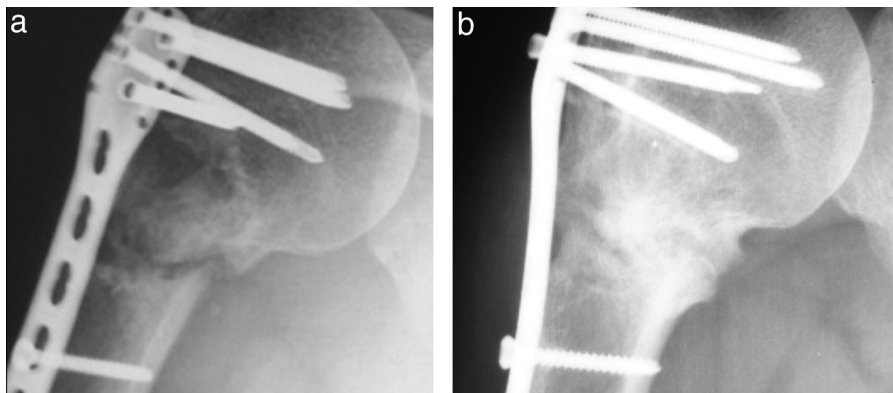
Radiographic images (female, aged 65 years, NUSS 40) showing non-union at the humeral neck before (1a) and 6 months after (1b) the application of growth factors in monotherapy (rh-BMP-7) without changing osteosynthesis.
